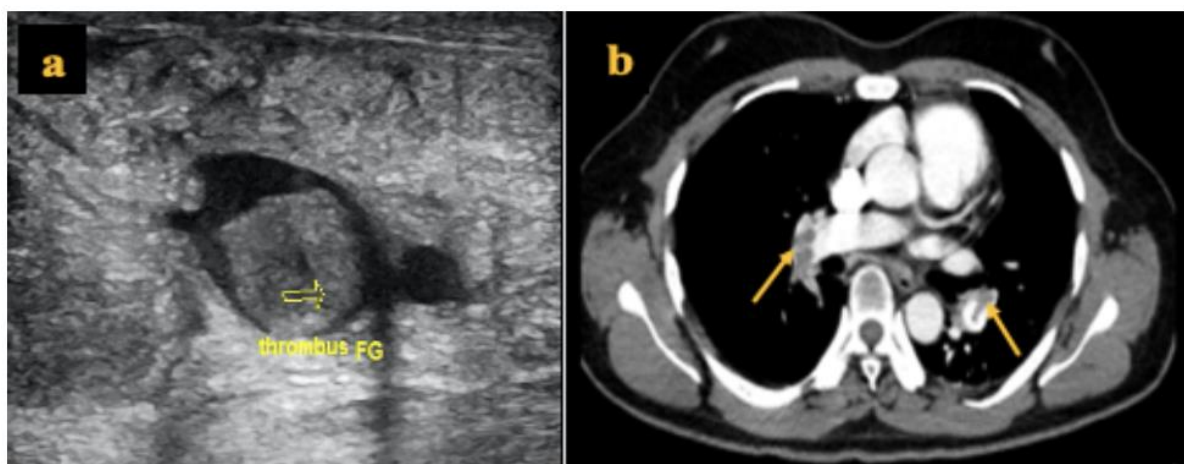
(a) The venous Doppler ultrasound at the crural level reveals a thrombus (indicated by the yellow arrow) within the vein. (b) contrast-enhanced axial chest CT scan shows a bilateral endoluminal defect at the level of the right and left pulmonary lobes (marked by the arrows)
